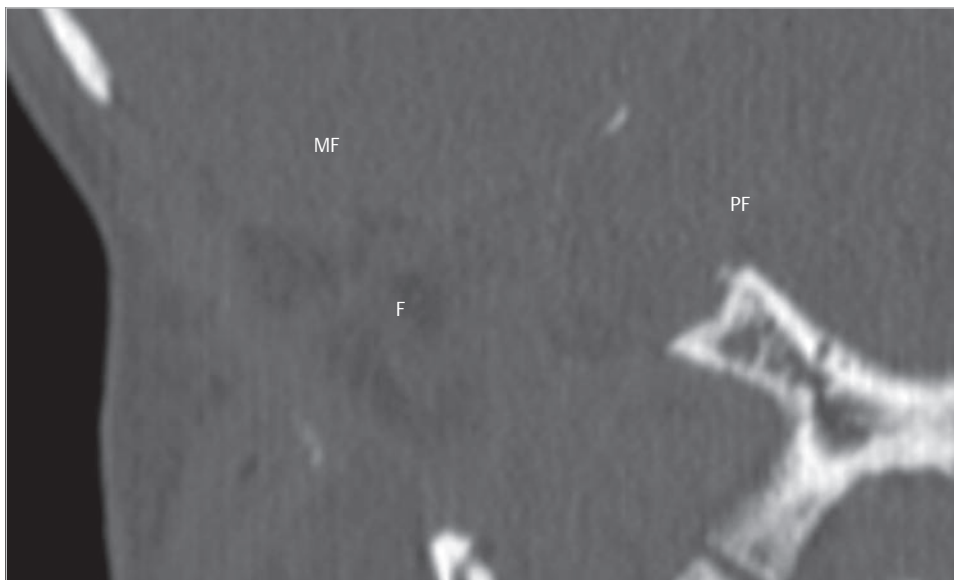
Coronal section of CT scan is shown. Note extensive uncovering of the dura from both the middle and the posterior fossae dura. F, abdominal fat; MF, middle fossa; PF, posterior fossa.
